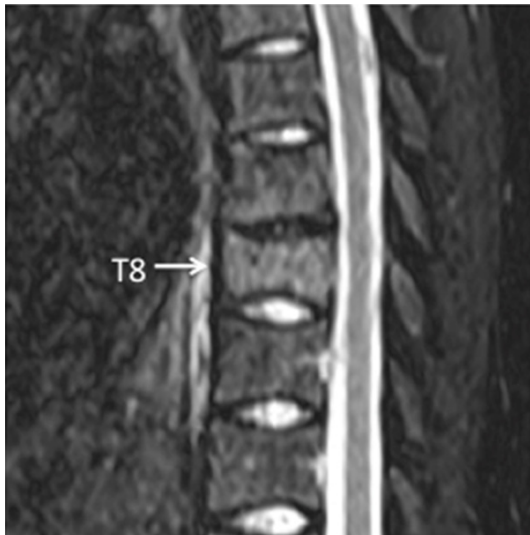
MRI of STIR sequence showed abnormal hyperintense of T8.
